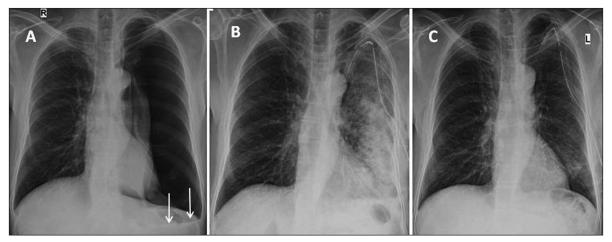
Serial chest radiographs. (A) On presentation showing a large pneumothorax with minimal fluid (arrows) on left side. (B) After 4 h of tube thoracostomy showing complete expansion of left lung with peripheral ground-glass haziness in upper and dense air-space opacity over mid and lower zones with chest tube in situ. (C) After 72 h showing complete resolution of the radiographic abnormality
